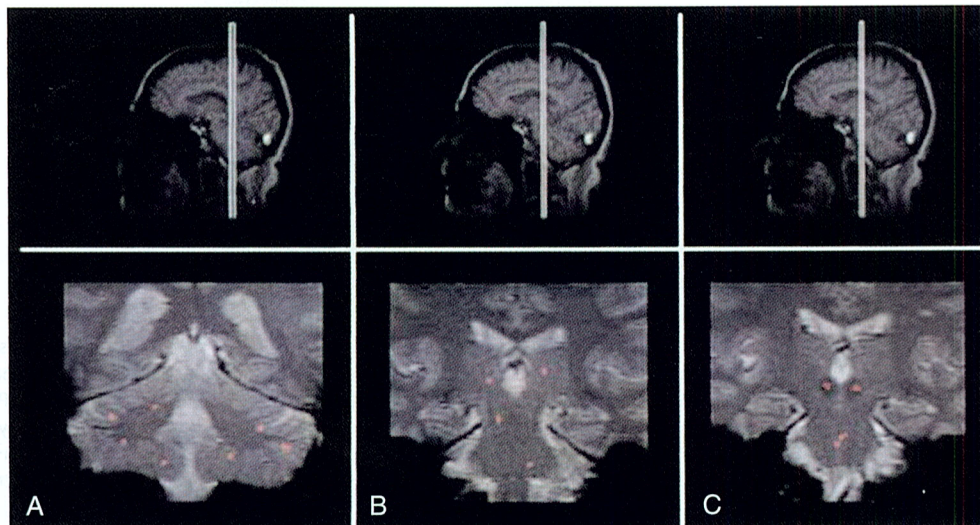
Functional brain changes associated with periodic limb movements (PLM) (functional magnetic resonance imaging). Neural responses associated with combined sensory leg discomfort and PLM during wakefulness in a patient with idiopathic restless legs syndrome (RLS). Activations are superimposed on three coronal T2-weighted magnetic resonance imaging sections, and the extents of activated areas were significant at $P < .05$ corrected for multiple comparisons. Activations were located in the bilateral cerebellum (A), thalamus (B), red nucleus (C), and the brainstem (pons and mesencephalon; B, C). (From Bucher SF, Seelos KC, Oertel WH, Reiser M, Trenkwalder C. Cerebral generators involved in the pathogenesis of the restless legs syndrome. *Ann Neurol.* 1997;41:639-645. Copyright 1997, with permission from John Wiley and Sons.)
